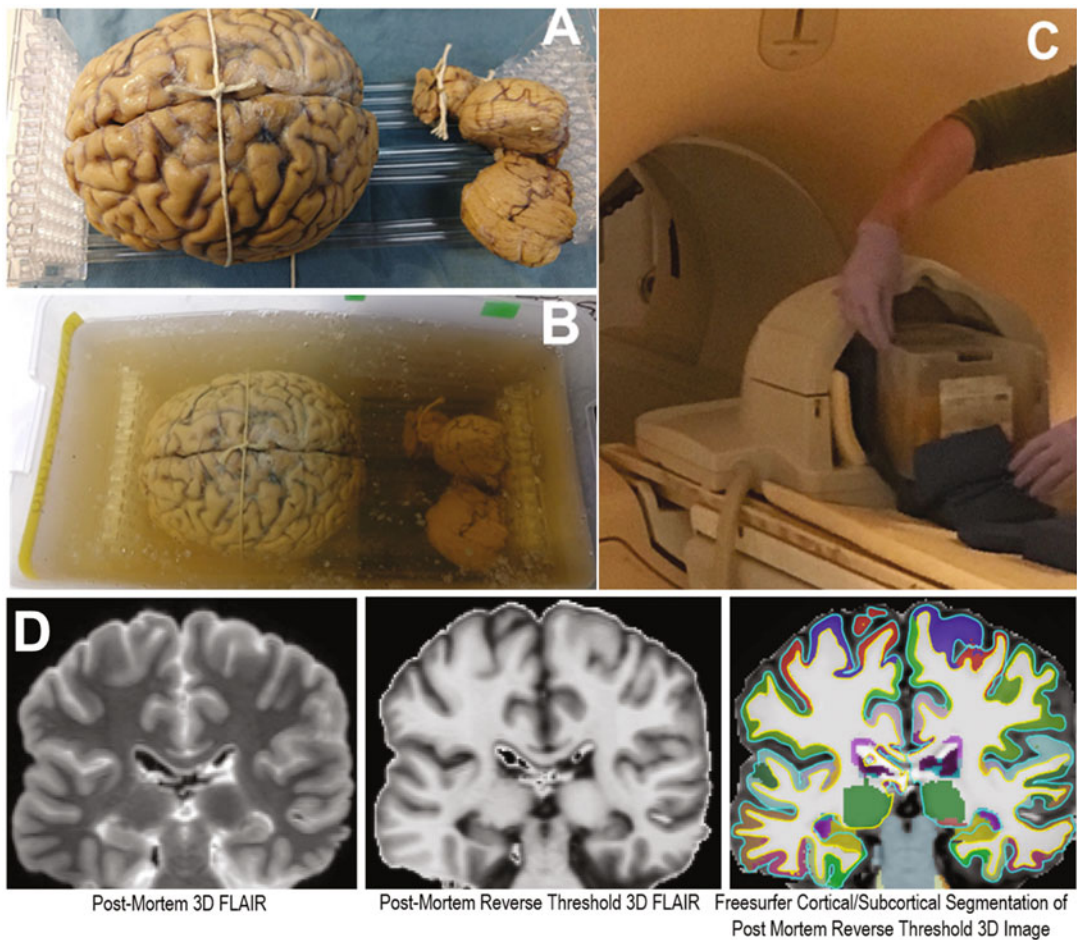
Brain embedding and imaging. The brain is first oriented on plastic scaffolding (a) and placed in a container that is then filled with agarose gel (b). After the block solidifies it is imaged in 3 T MRI machine (c). The generated images can be manipulated, and standard imaging analysis software leveraged (Post-Mortem 3D FLAIR, Reverse-Threshold 3D FLAIR, FreeSurfer Cortical/Subcortical segmentation) (d)
